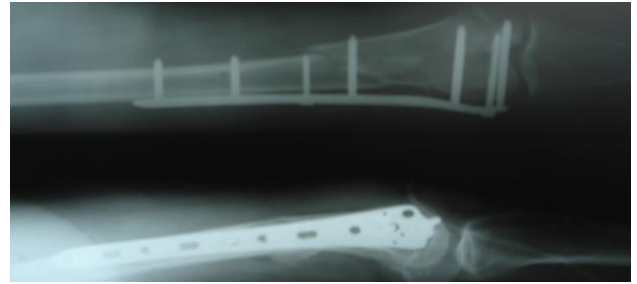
(a): Immediate post-operative x-rays.
